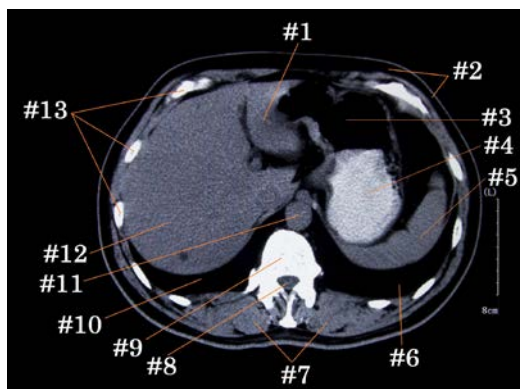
CT axial cross-sectional image of the upper abdomen.
